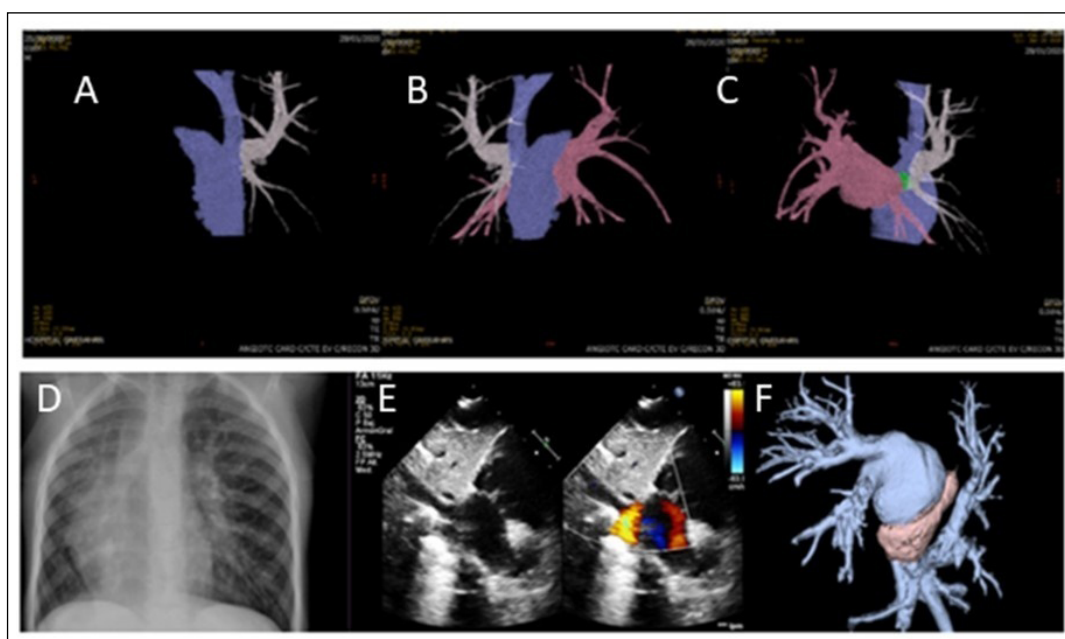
(A-C) Computed tomography (CT) angiography with three-dimensional (3D) reconstruction in a patient with a diagnosis of sinus venosus atrial septal defect associated with partial anomalous right pulmonary venous return. (A) White: right upper pulmonary vein draining into the superior vena cava. (B) Pink: fusion image of the remaining three pulmonary veins draining normally into the left atrium. (C) Green: image of a small sinus venosus-type atrial septal defect. (D-F) Patient with a diagnosis of Scimitar syndrome. (D) Chest X-ray in Scimitar syndrome: cardiac dextroposition, right lung hypoplasia, and a curvilinear linear opacity along the right cardiac border extending from the hilum toward the cardiophrenic angle, consistent with the characteristic “scimitar sign.” (E) Subcostal color Doppler echocardiographic view demonstrates right pulmonary venous drainage into inferior vena cava. (F) CT scan demonstrates all right pulmonary venous drainage into inferior vena cava.
